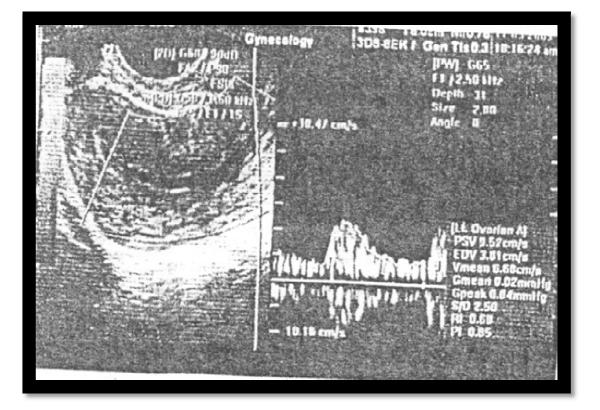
A 23 old patient who was pregnant ± 10 week's ultrasound confirmed the diagnosis of missed abortion, and was scheduled for elective termination of pregnancy.
